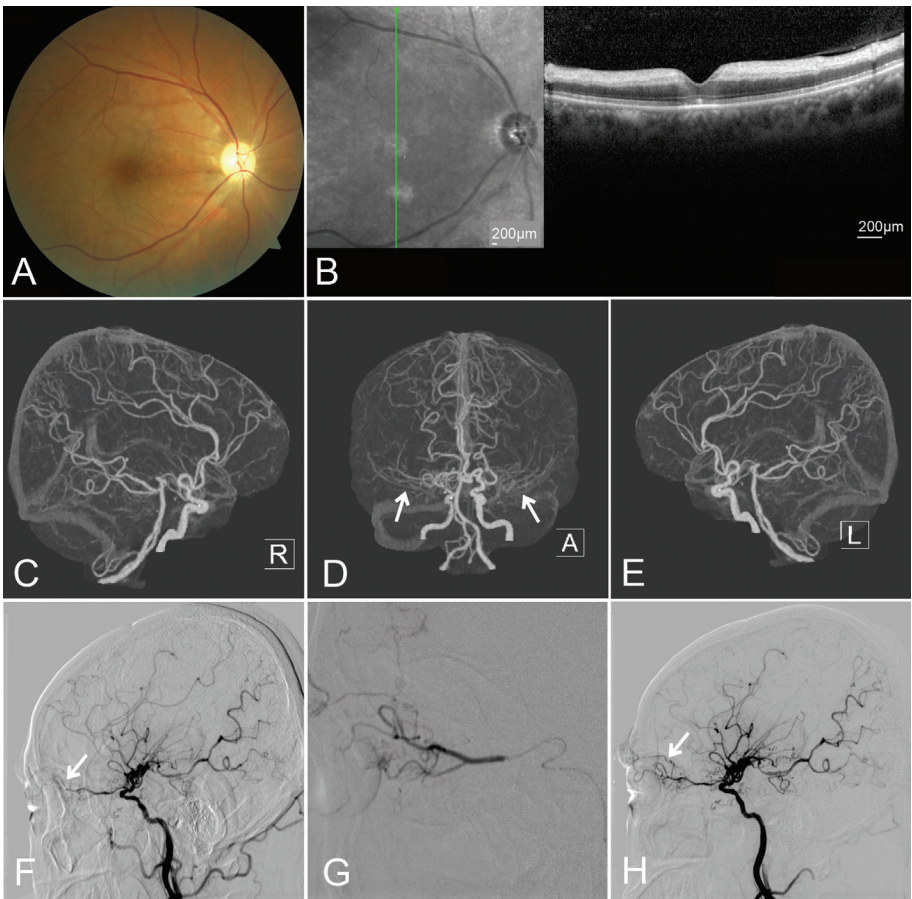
Case 3 imaging findings A-B: Fundus photograph and OCT image of the right eye at presentation; C-E: CTA image showing bilateral MMD; F: Cerebral angiography before thrombolytic injection; G: Cerebral angiography during the thrombolytic injection; H: Cerebral angiography after the thrombolytic injection. OCT: Optical coherence tomography; CTA: Computed tomography angiography; MMD: Moyamoya disease.
